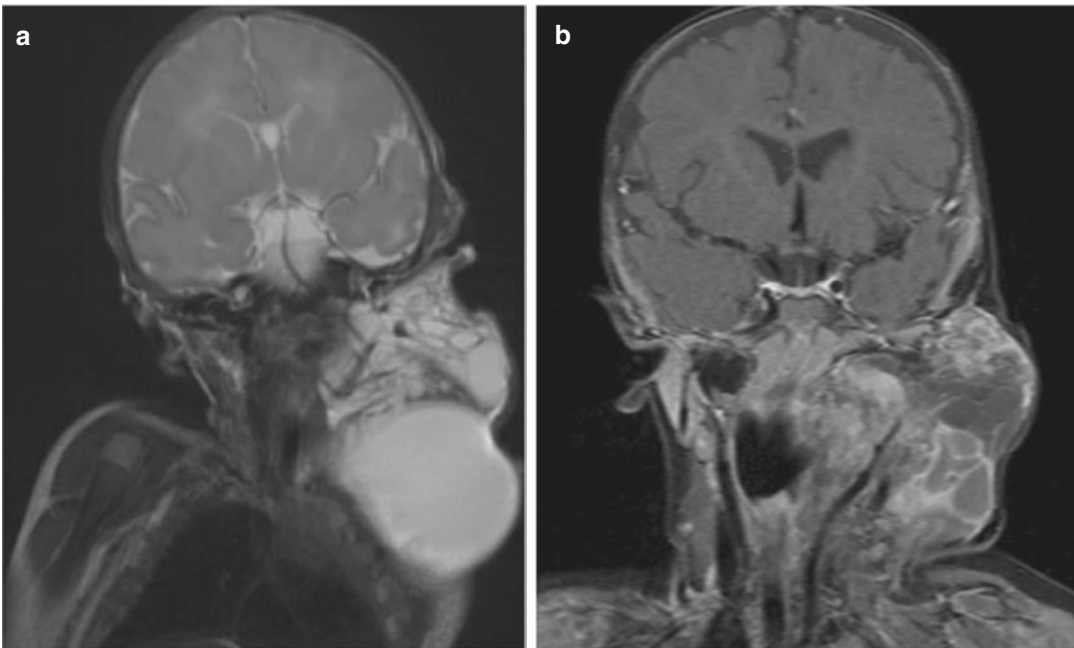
Cervical lymphangioma of the left side of a 6-month-old boy on T2-weighted coronal MR images (a). The liquid isointense cystic parts of different size are bordered by thin hypointense cyst walls. The size of the vascular malformation and its extension into the deep muscles of the neck causes limited mobility of the neck and head
